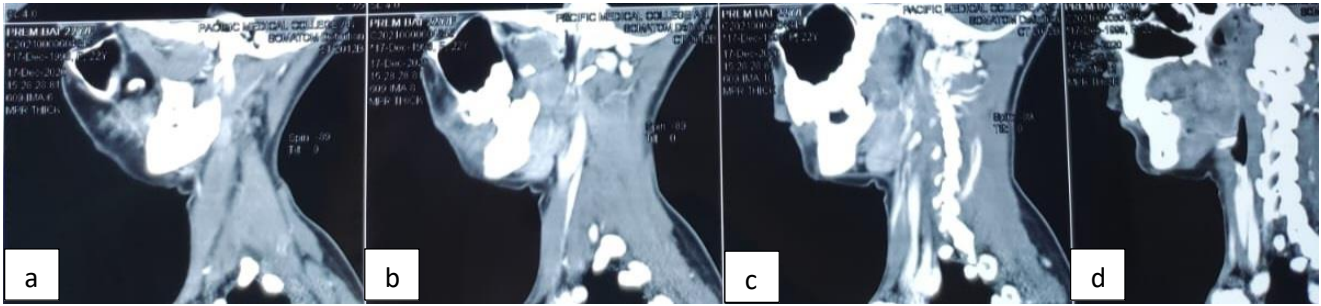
(a-d) CT-scan showing clear cell (sagittal section).
